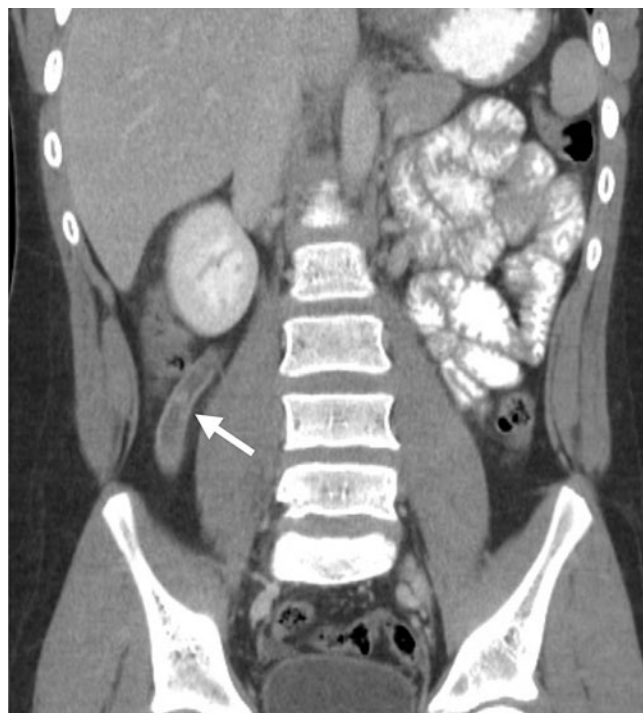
Appendicitis. Coronal reformatted computed tomography (CT) scan shows a dilated, inflamed, fluid-filled appendix (arrow) along the lateral aspect of the right psoas muscle
